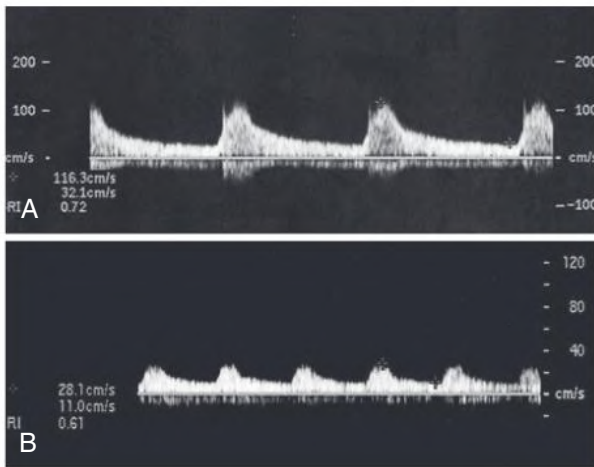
Renal Artery Color Doppler Image and Spectral Imaging. (A) Normal renal artery tracing shows rapid systolic upstroke and early systolic peak velocity (~100 cm/s). (B) Tardus-parvus waveform demonstrates slow systolic upstroke (acceleration) and decreased peak systolic velocity (~20 cm/s) associated with renal artery stenosis. Note different scales on vertical axis.
